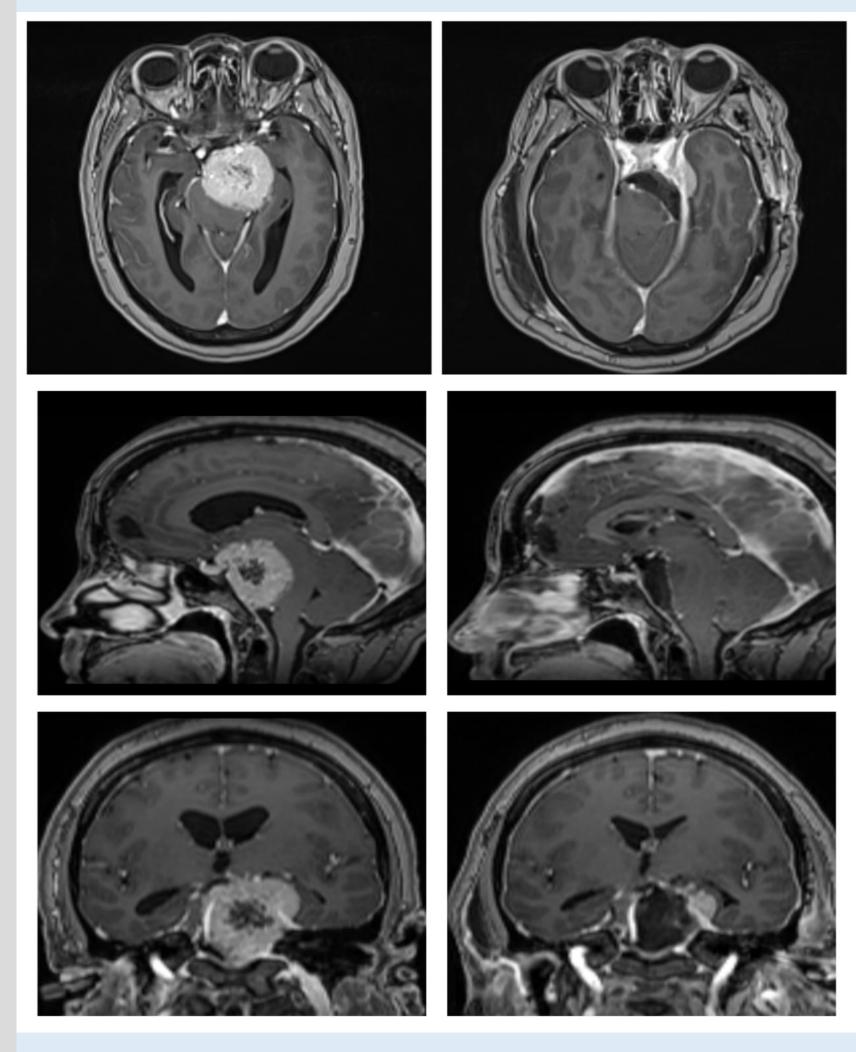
above: Petro-clival meningioma resection: T1 +Gad sequence MRI with Axial, sagittal and coronal views of the tumour pre-operatively (on the left of each view) and post-operatively (right sided images) after using the endoscopic keyhole approach for resection. Near total resection was achieved in this case.
